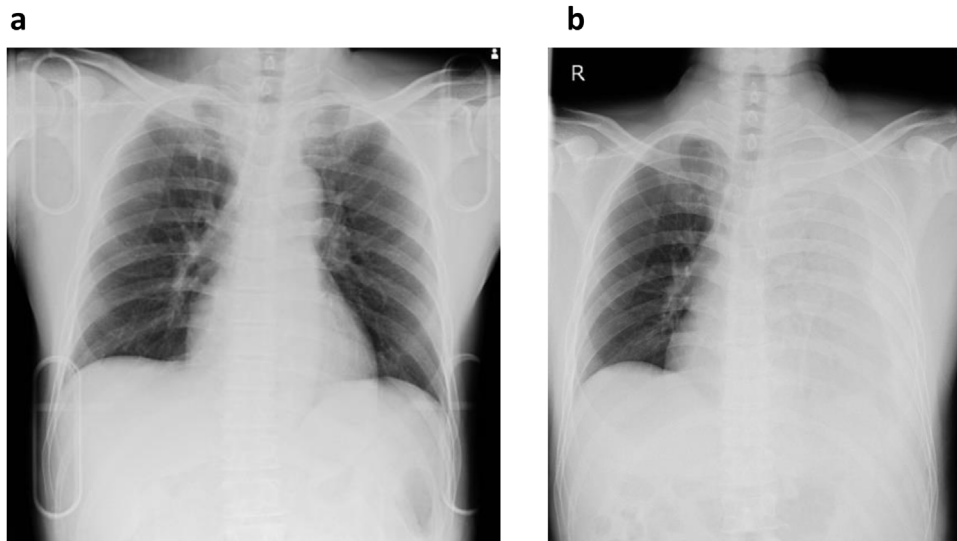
(a) Chest X-ray on admission showed no evidence of hemothorax.
